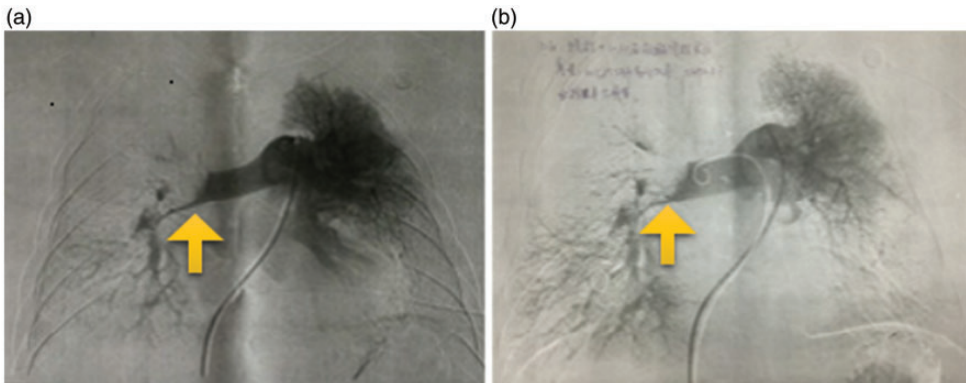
Pulmonary artery computed tomography angiography showed a lack of obvious effects of thrombolysis treatment in the right pulmonary artery trunk. (a) Before interventional therapy. (b) After therapy.
